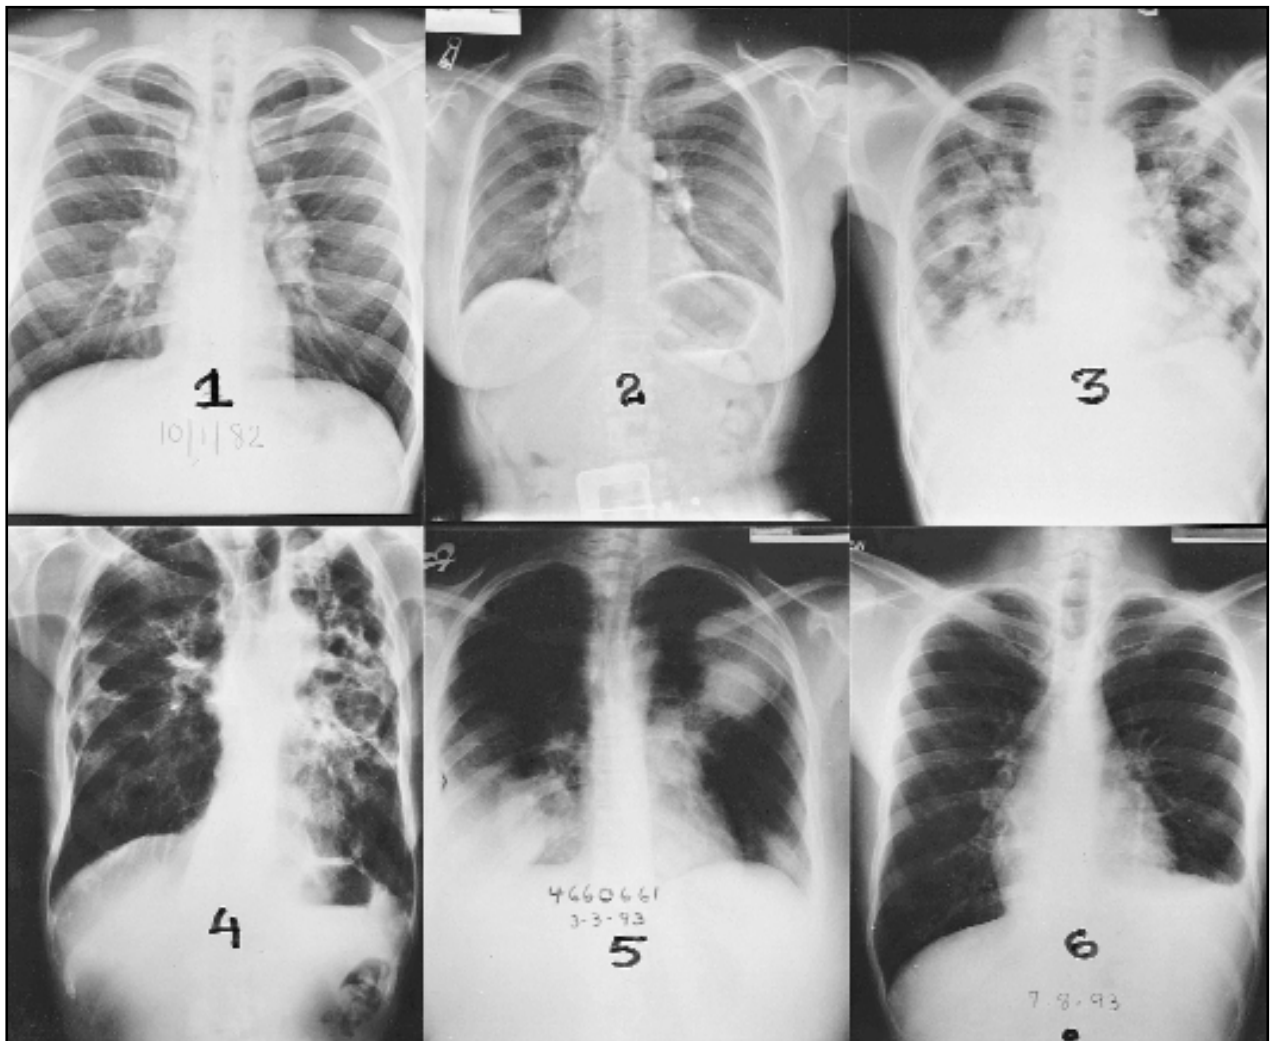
Chest radiographic features of sarcoidosis:
